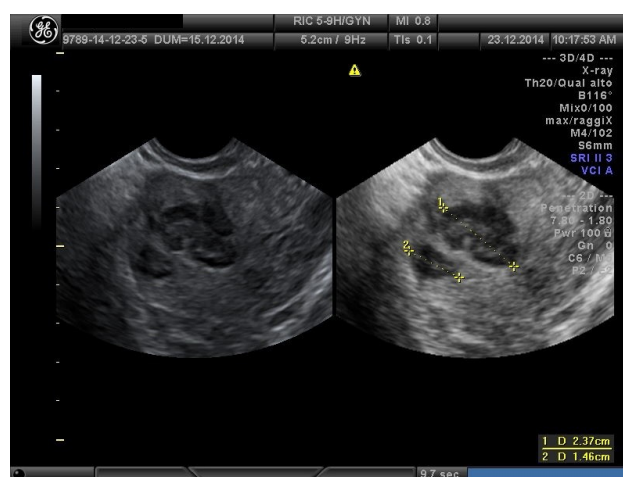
The ultrasound view of submucosal uterine fibroid. Ultrasound view of submucosal uterine fibroids (1 - submucosal uterine fibroid with diameter of about 2.37 cm; 2 - submucosal uterine fibroid with diameter of about 1.46 cm).
